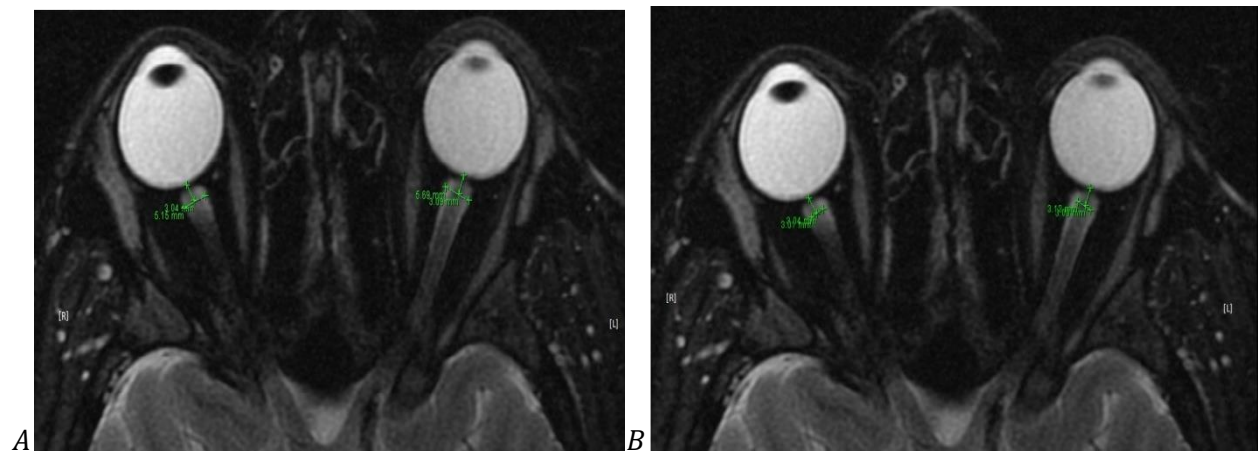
Example of measurement method; axial T2-weighted FSE image demonstrates bilateral presentation of the A.ONSD 3mm behind globe, B.OND 3mm behind globe in a 25 - year-old female and the patient had no diabetic, or hypertension.
